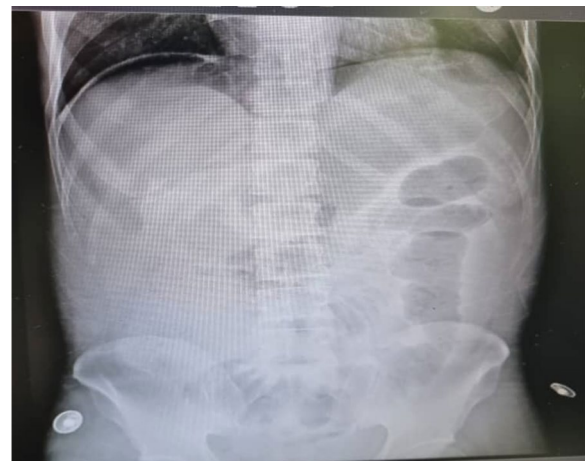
X-ray of the abdomen and pelvis
